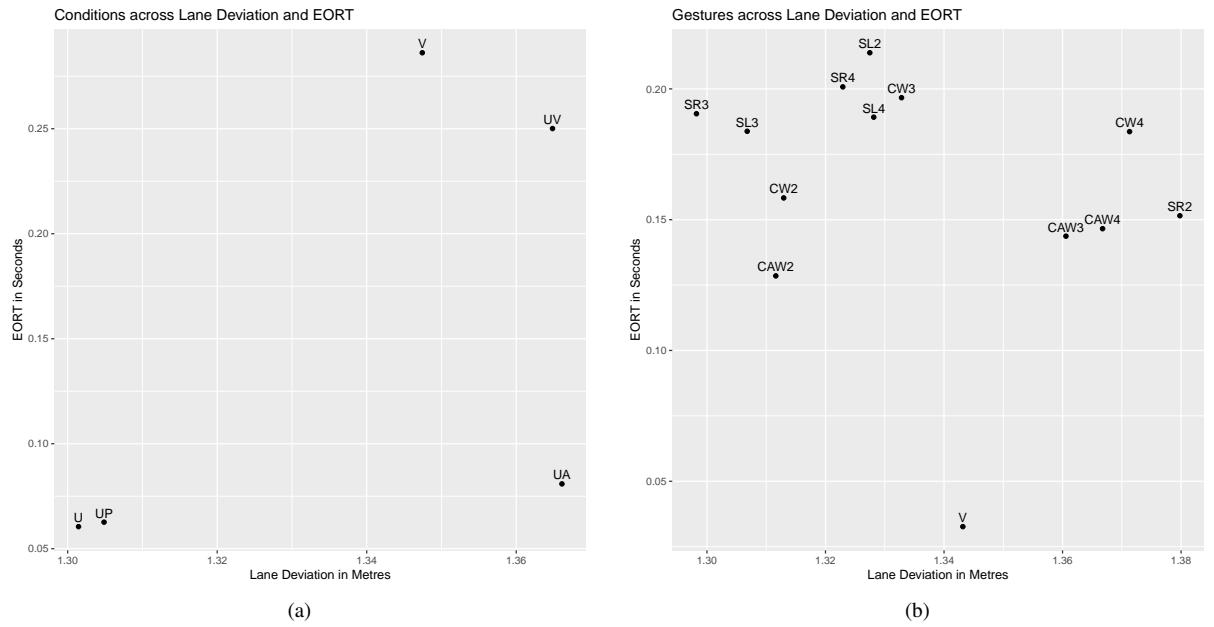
Left: Gaze behaviour and driving performance across feedback types (V: visual; U: ultrasound; UV: ultrasound-visual; UA: ultrasound-audio; UP: ultrasound-peripheral). Right: Gaze behaviour and driving performance across gestures (CW: Clockwise, ACW: Anti-clockwise, SL: Swipe Left, SR: Swipe Right, V: Victory). The scales on the axes do not start from 0; the reason behind this choice is to make the output readable (otherwise the dots would be displayed close together and on top of each other).
